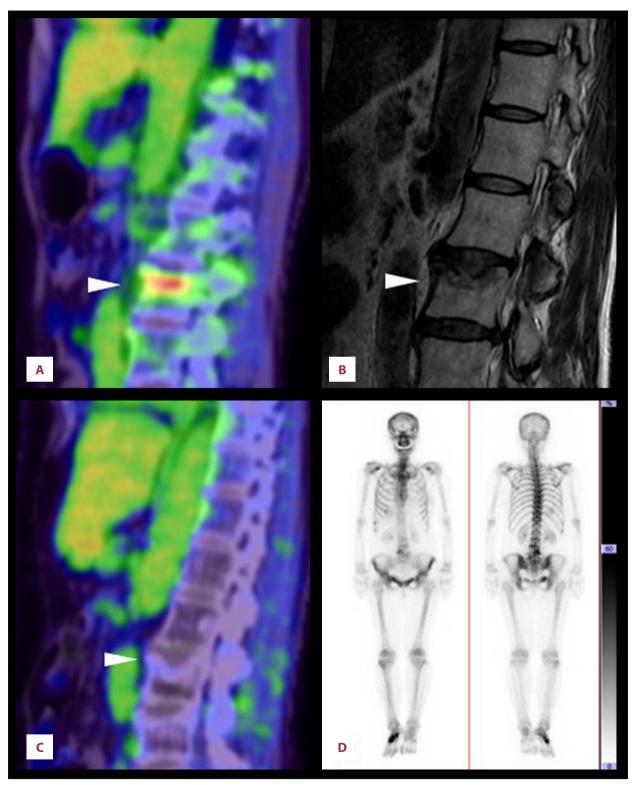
Changes in bone metastasis on ¹⁸F-FDG-PET/CT imaging, magnetic resonance imaging (MRI), and bone scintigraphy. ¹⁸F-FDG-PET/CT (A) and MRI (B) revealed bone metastasis in the 3rd lumbar vertebra (white arrowhead) in December 2014. Three years and 10 months later, ¹⁸F-FDG-PET/CT (C) showed no abnormal accumulation in the 3rd lumbar vertebra (white arrowhead). Bone scintigraphy in June 2019 showed no abnormal accumulation in the 3rd lumbar vertebra and no other bone metastases (D).
